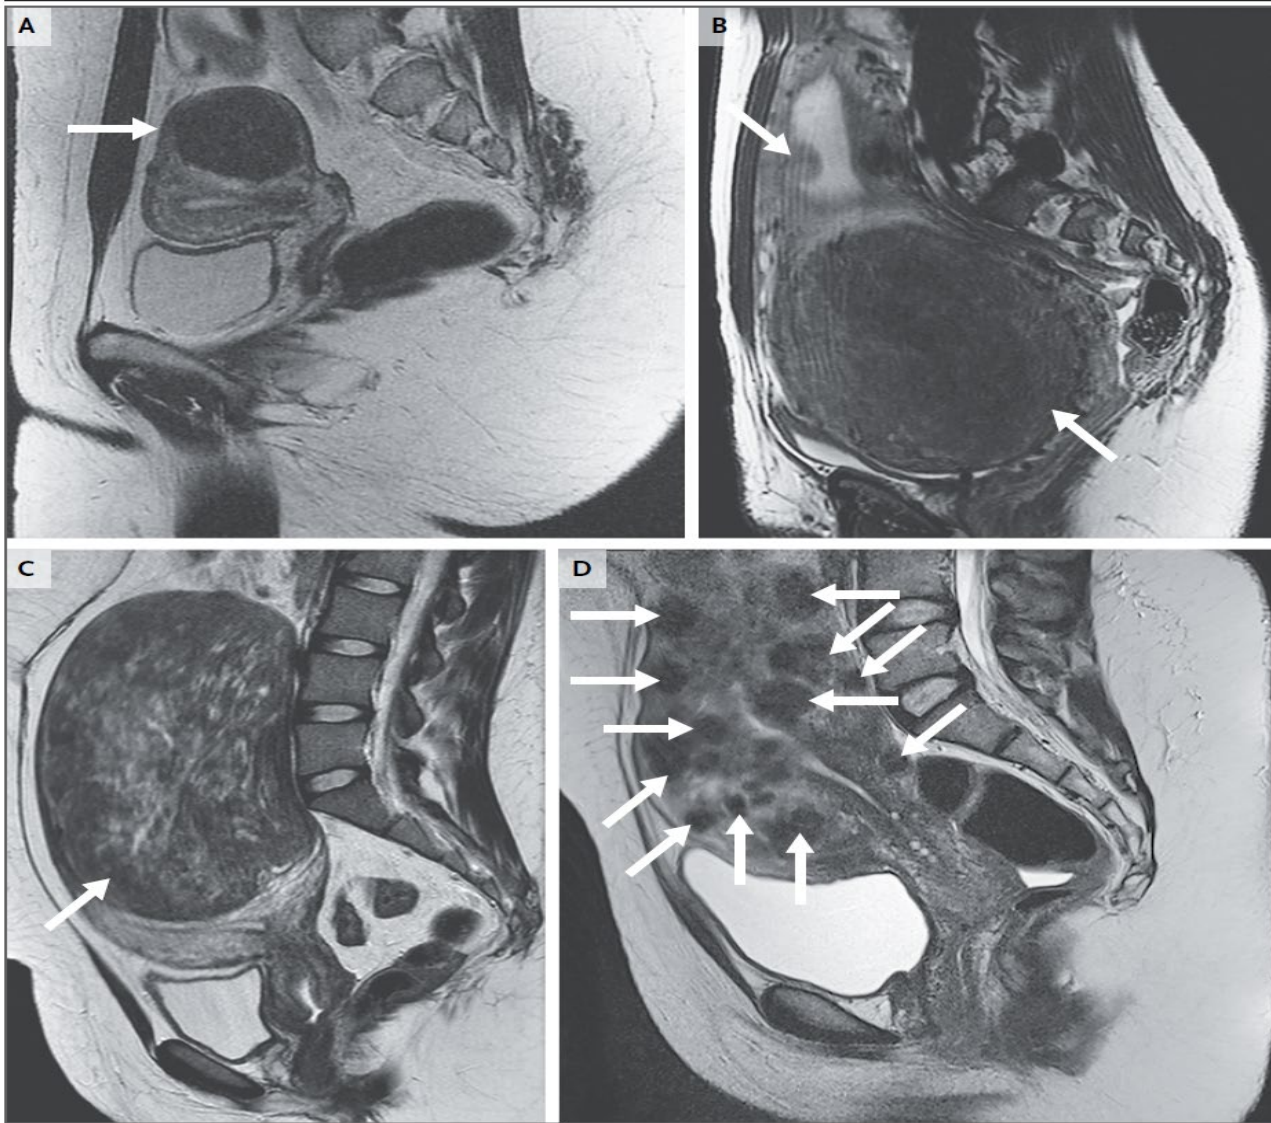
Magnetic Resonance Images of Fibroids.
